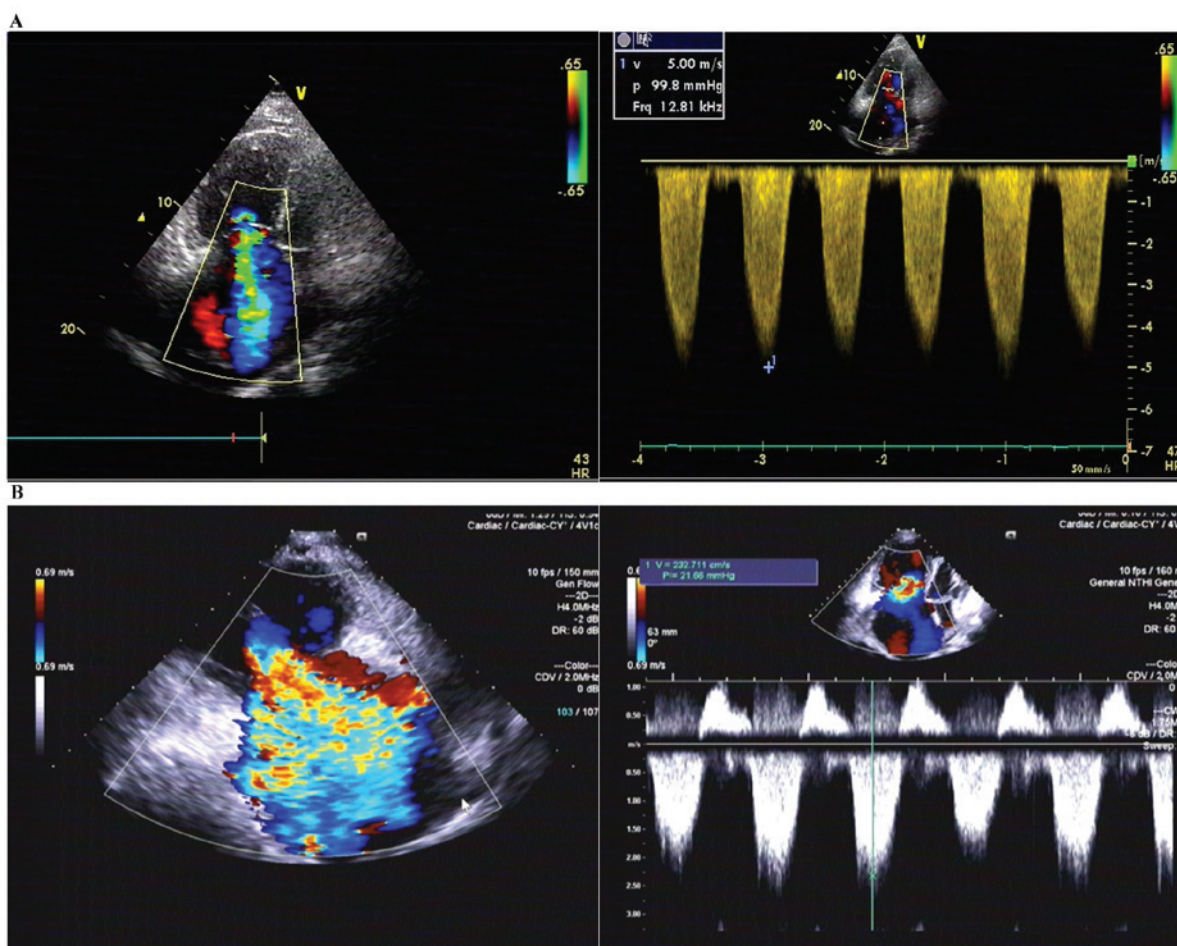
Echocardiography performed on a 61-year-old female with pulmonary hypertension. (A) Echocardiography revealed intermediate to severe tricuspid regurgitation with a Vel of 500 cm/sec and a PG of 99.8 mmHg in August 2011. (B) Echocardiography, performed 3 years later, revealed severe tricuspid regurgitation with a Vel of 232 cm/sec and a PG of 21.6 mmHg. Vel, velocity; PG, pressure gradient.
